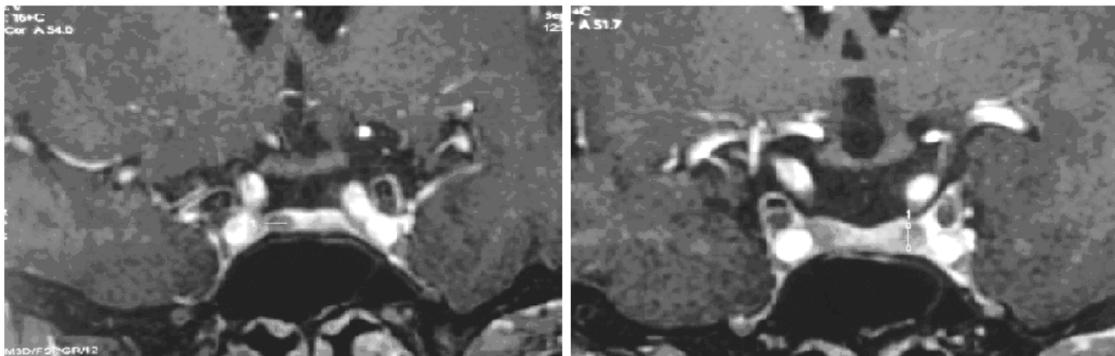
Postoperative control. Magnetic resonance imaging (MRI) of the pituitary showing reduced intrasellar tumor on the right side and hypodense mass on the left side of the fossa suggesting possible pituitary hyperplasia or multiple adenomas.
